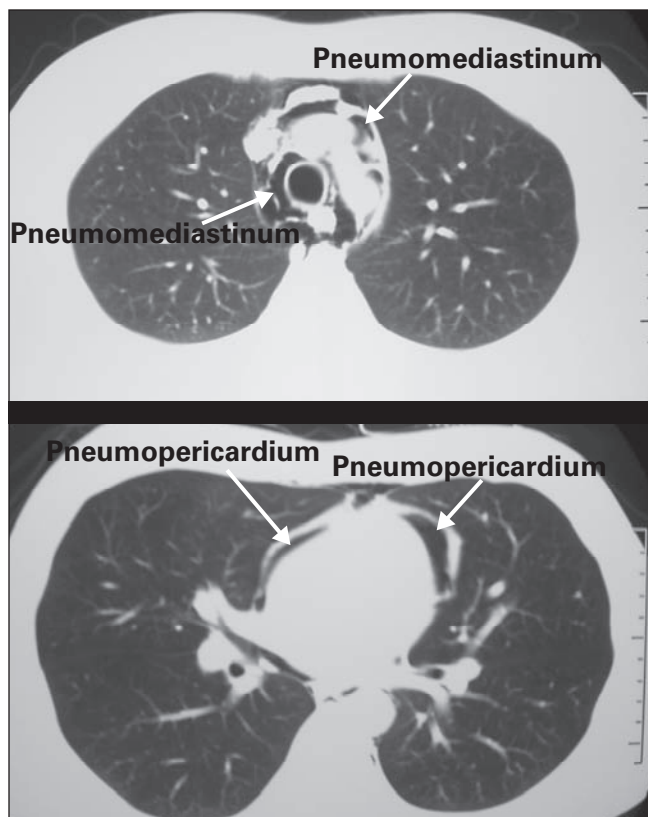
Subsequent computed tomography of the chest confirmed pneumomediastinum and pneumopericardium at multiple levels.
